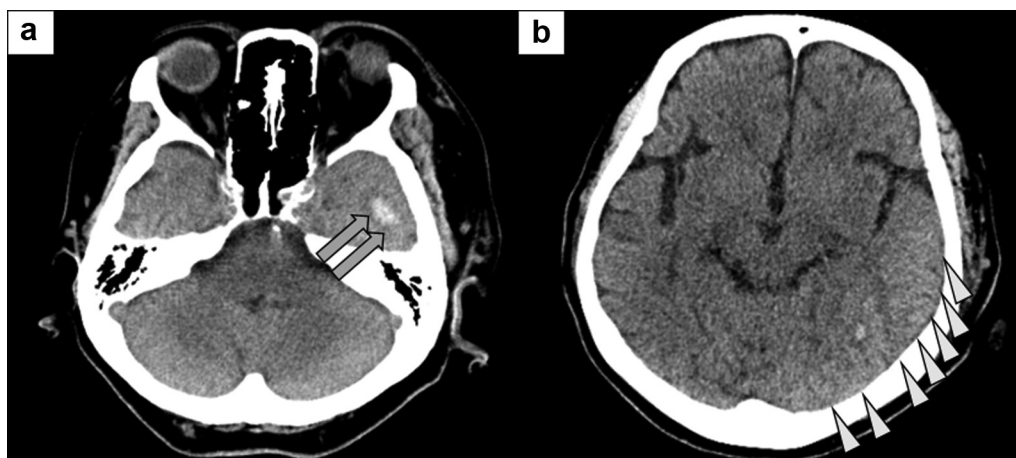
Plain computed tomogram of the head at the patients' hospital admission. There was (a) a high-density area in the left temporal lobe, indicating a cerebral hemorrhage (arrows). (b) In addition, (b) a widely spread, high-density area was detected in the left occipital lobe, indicating congestive edema (arrowheads); congestion of contrast agent in the left hemisphere demonstrated this finding.
